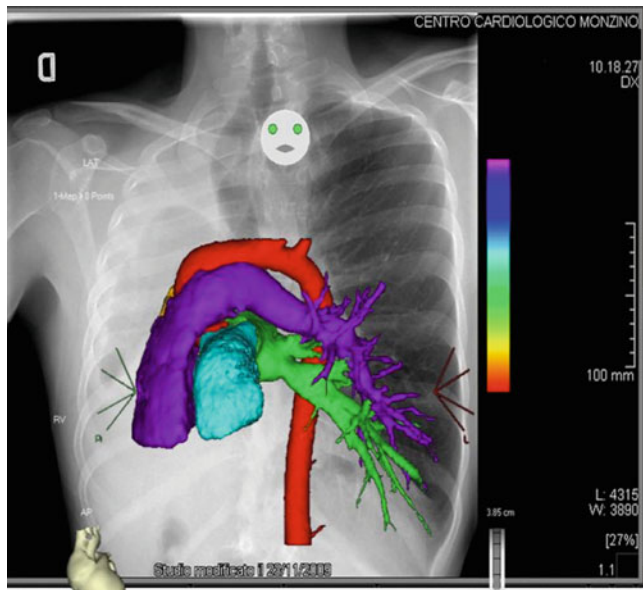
The case of a patient with right-positioned heart (right heart displacement) secondary to right pulmonary agenesis is shown. The TC scan reconstruction is superimposed on a posteroanterior chest x-ray view. Light blue represents the left ventricle; purple the right ventricle giving rise to the left pulmonary artery; red the ascending aorta; green the left atrium with the left pulmonary veins. The right atrium is covered by the right ventricle; right pulmonary veins are absent
